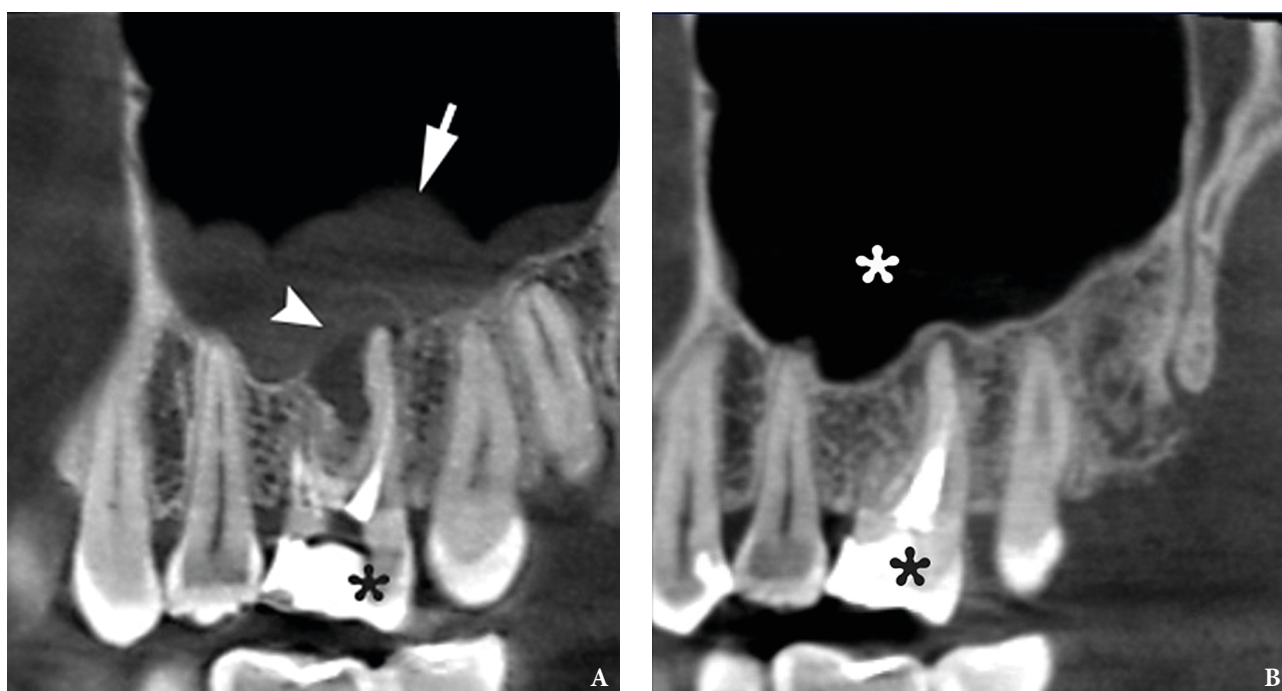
A – A sagittal CBCT scan in a 25-year-old lady before endodontic retreatment shows periapical lesion (arrowhead) around the apices of a tooth 1.6 (asterisk) and chronic maxillary sinusitis (arrow). B – A 8-month follow-up sagittal CBCT scan shows no signs of periapical lesion around the apices of a tooth 1.6 (black asterisk) and no chronic inflammation in the maxillary sinus (white asterisk). Images of Figure 1 are courtesy of Dr. Mariia A. Zimina, Zimina Dental Clinic, Kyiv, Ukraine.
